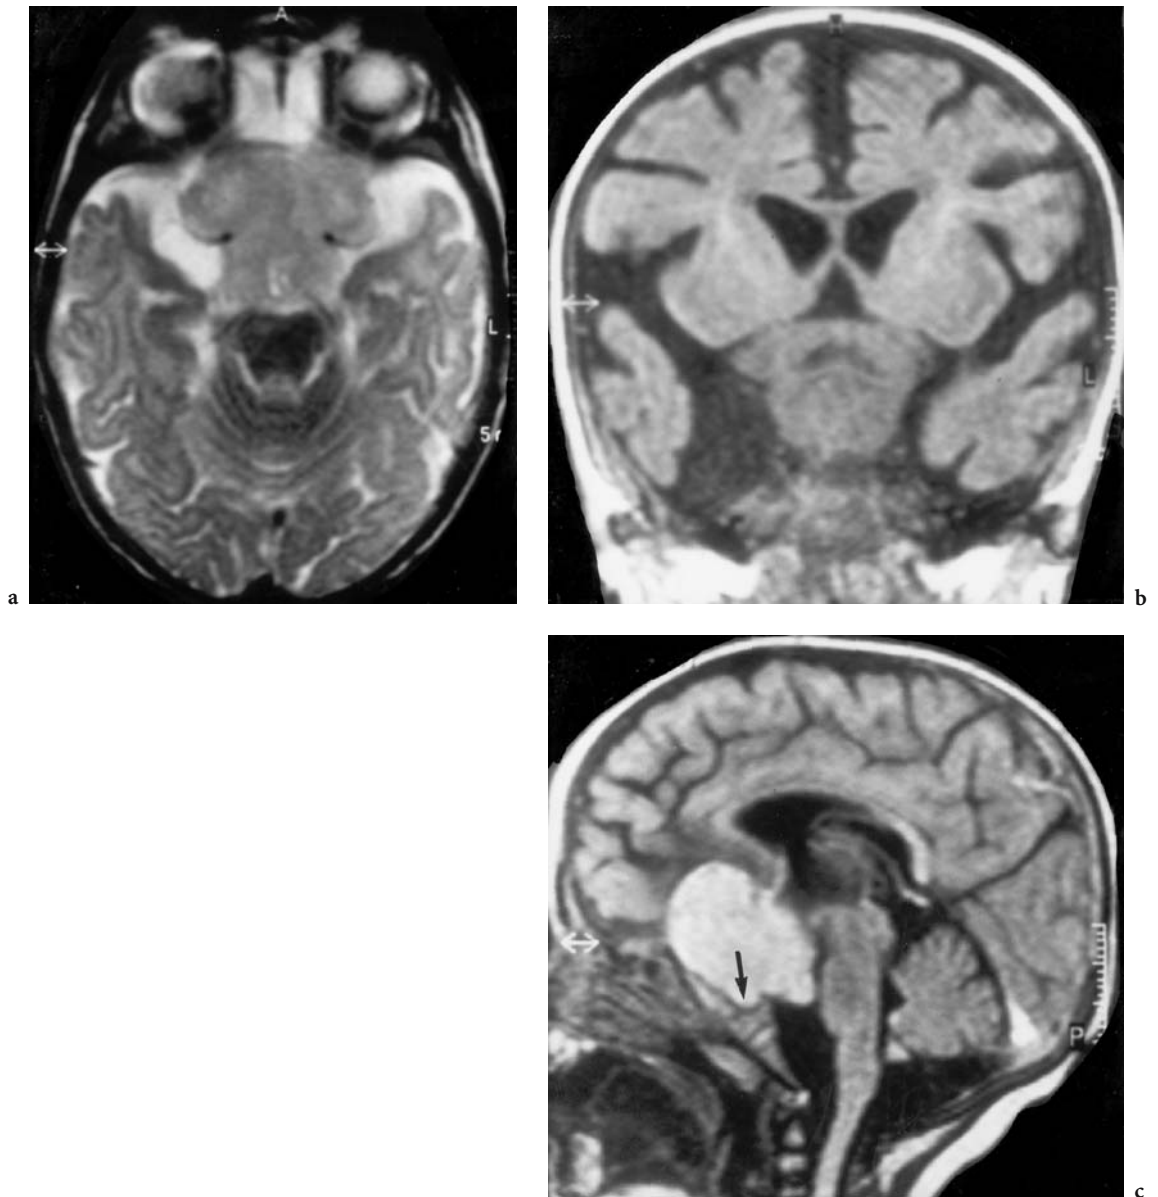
A 5-month-old girl with persisting vertical nystagmus, intermittent strabismus, and increased intracranial pressure. Diagnosis: astrocytoma (WHO II) of the chiasm with infiltration of the left optic nerve. MRI: a Axial T2-weighted view with a very large, space-occupying, isointense lesion located in a widened suprasellar cistern, depressing and spreading the basal vessels. b Coronal T1-weighted native view demonstrating pressure exertion on the widened third ventricle by the central hypointense (necrotic) tumor. c Midsagittal, T1-weighted, contrast-enhanced view with demarcation of the entire enhancing tumor, compressing and displacing the brainstem, and extending into the posterior fossa. Note widening of the entrance of the otherwise normally configured sella (*arrow*). (With permission of Dr. Klusemann, Radiologische Gemeinschaftspraxis, Bad Homburg)
